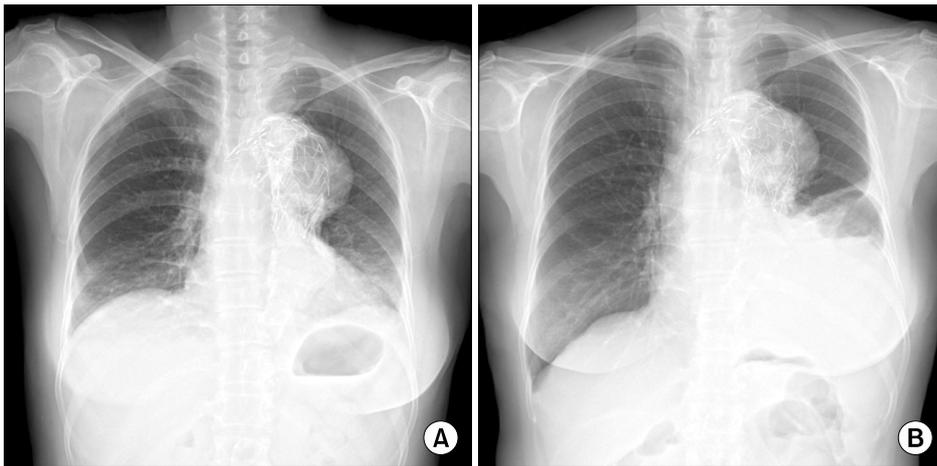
(A) Chest X-ray on discharge. (B) Chest X-ray on re-visit.
